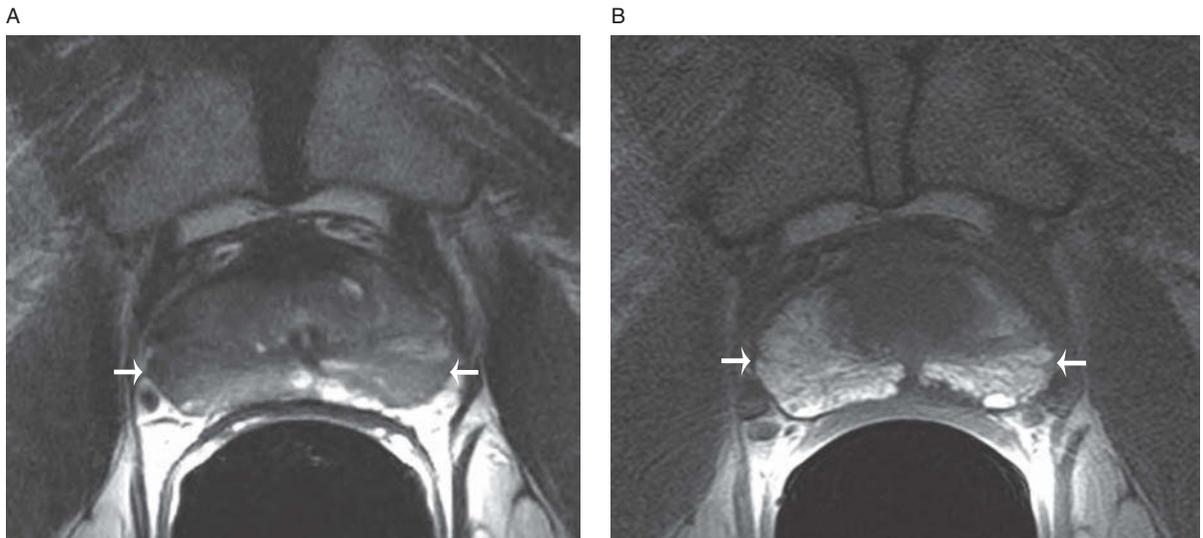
Post-biopsy hemorrhage in the peripheral zone of the prostate in a 55-year-old male. Axial T2-weighted image (A) reveals diffuse low signal intensity throughout the peripheral zone, right greater than left (arrows). Corresponding axial T1-weighted image (B) shows that the areas of low signal intensity on the T2-weighted image correspond to areas of high signal intensity blood products (arrows). No discrete tumor is identified on these MRI images.
